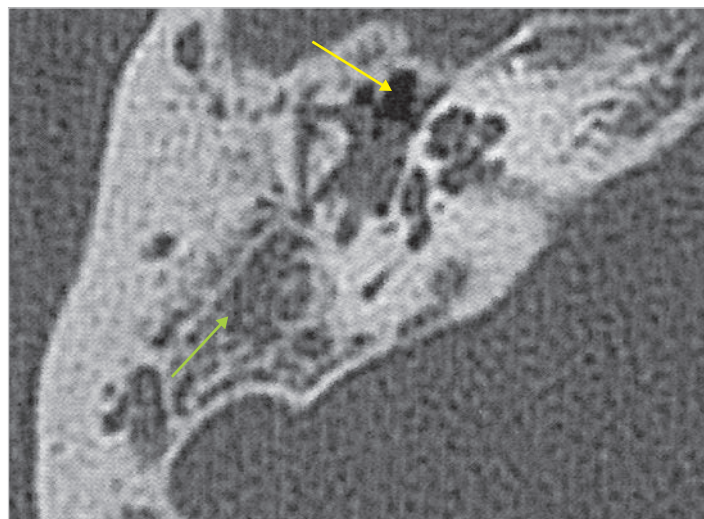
CT scan, axial view, of the same case. The anterior epitympanum is free from the disease (*yellow arrow*), while the mastoid (poorly pneumatized) is opacified (*green arrow*). Presence of cholesteatoma was verified during surgery.
